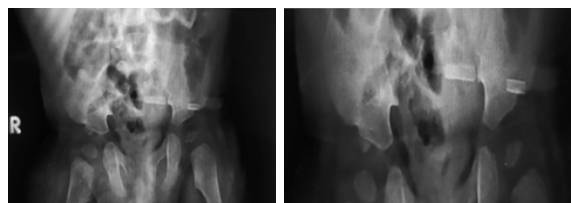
Radiograph of pelvis-AP view & magnified image depicting flared iliac bones, shallow acetabula with normal femoral heads.
